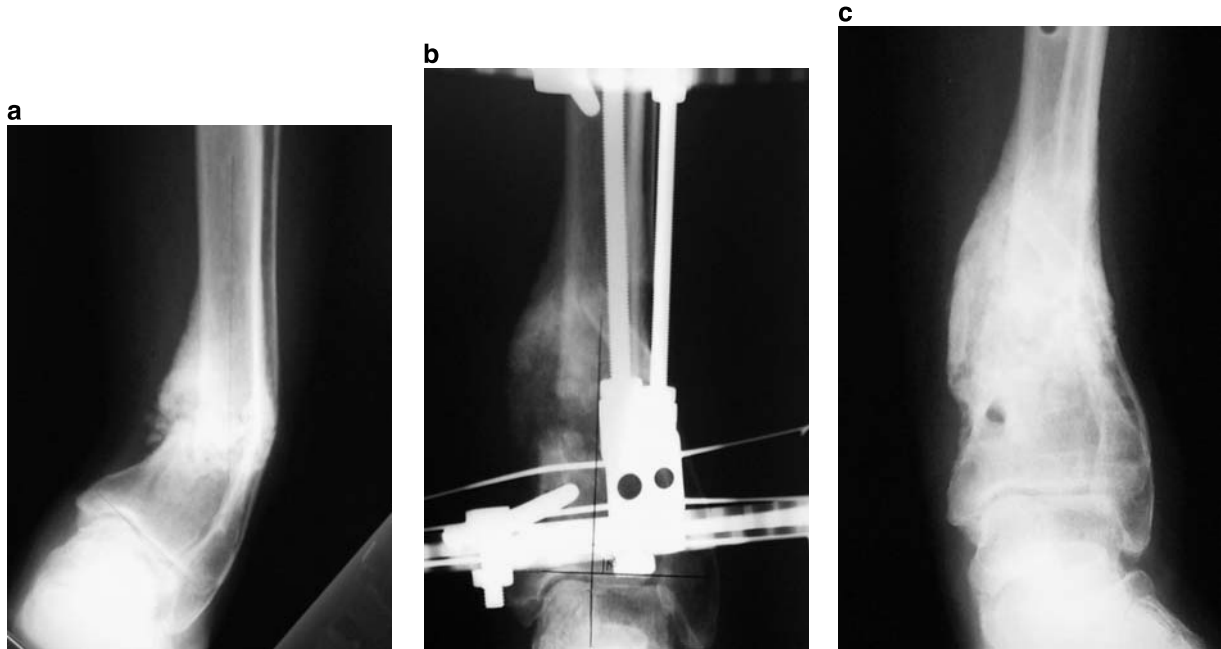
a AP x-ray showing a stiff nonunion with large varus deformity in a blind diabetic patient. This patient had a lateral ulcer at the apex of the fibula deformity. b Four weeks after application of the Ilizarov frame. The nonunion was not exposed and gradual distraction correction was performed. c Six months after frame removal showing healed nonunion without deformity
